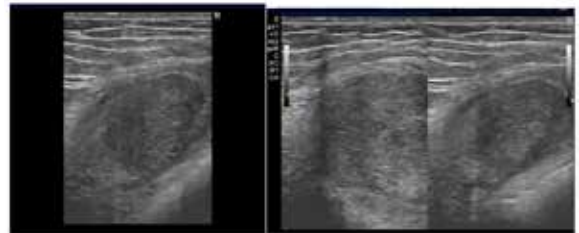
Ultrasound revealed an ovoid 12 cm heterogeneous solid hypoechoic nodule with well-defined, firm, fixed, well capsulated regular margins.
